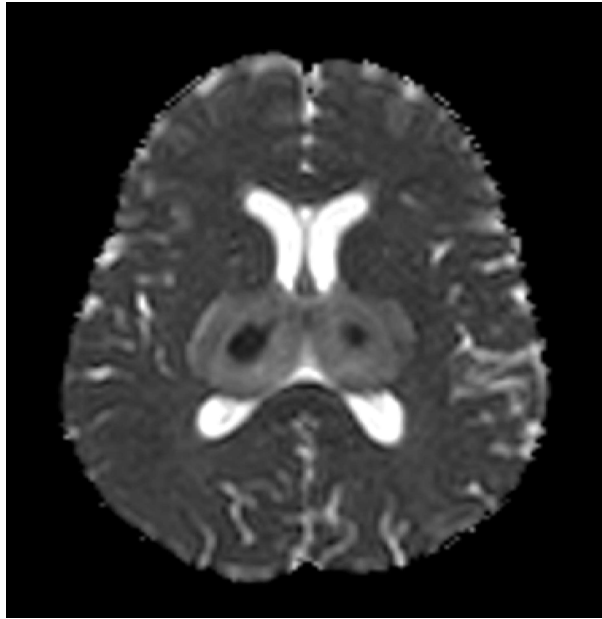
Axial DWI image showing diffusion restriction in bilateral thalami, contributing to the “double doughnut” appearance
